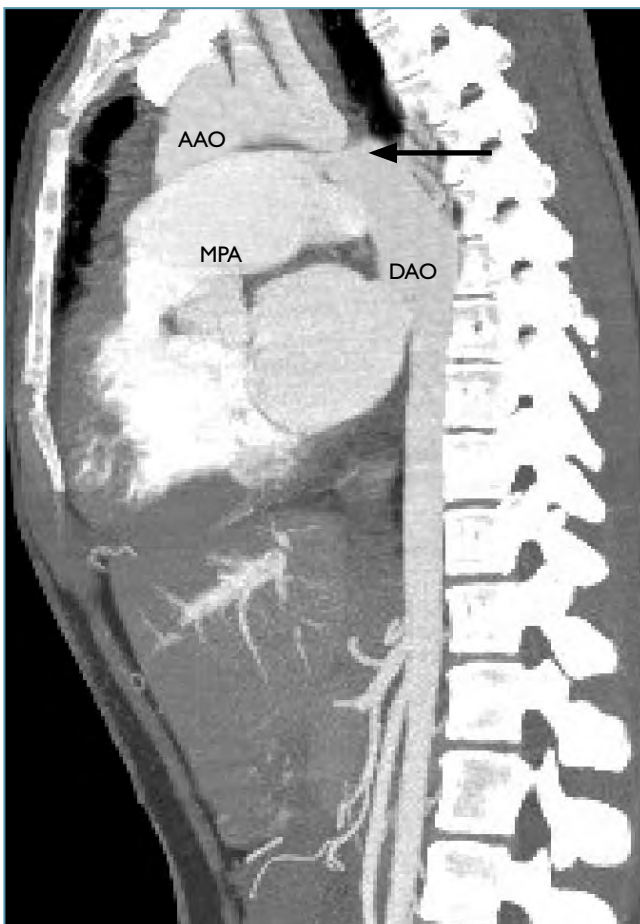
Spiral CT angiography scan demonstrating tight, discrete coarctation of the aorta and a large PDA (arrow).
